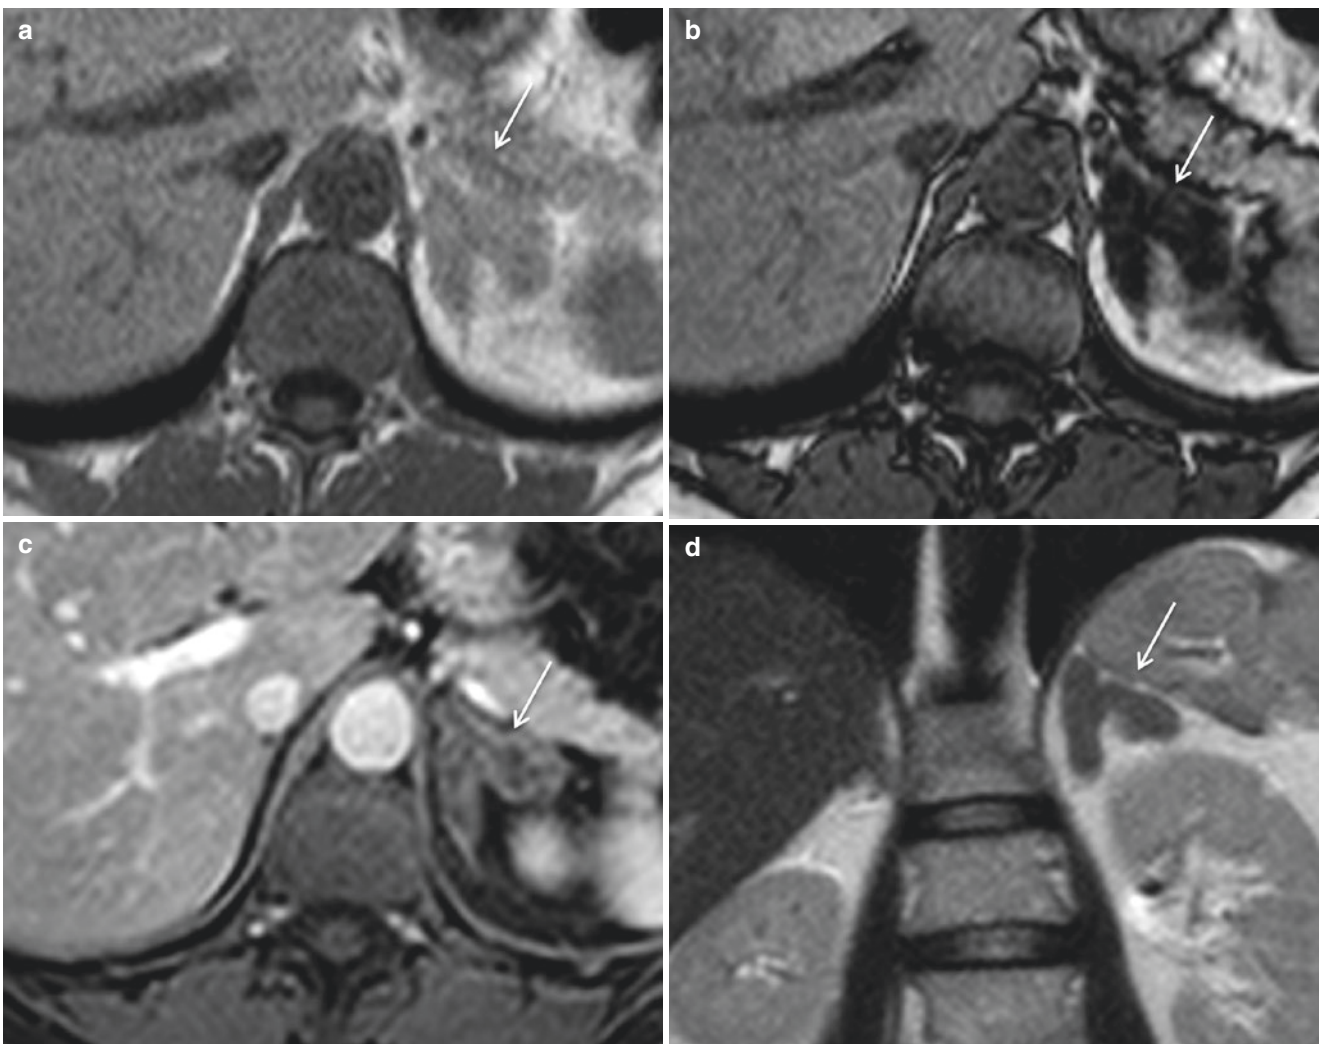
Adrenal hyperplasia. Accentuated diffuse enlargement of left adrenal gland showed on in-phase (a) and out-of-phase (b) axial T1-weighted, as well as on post-gadolinium axial T1-weighted (c) and coronal T2-weighted (d) images (white arrows)
